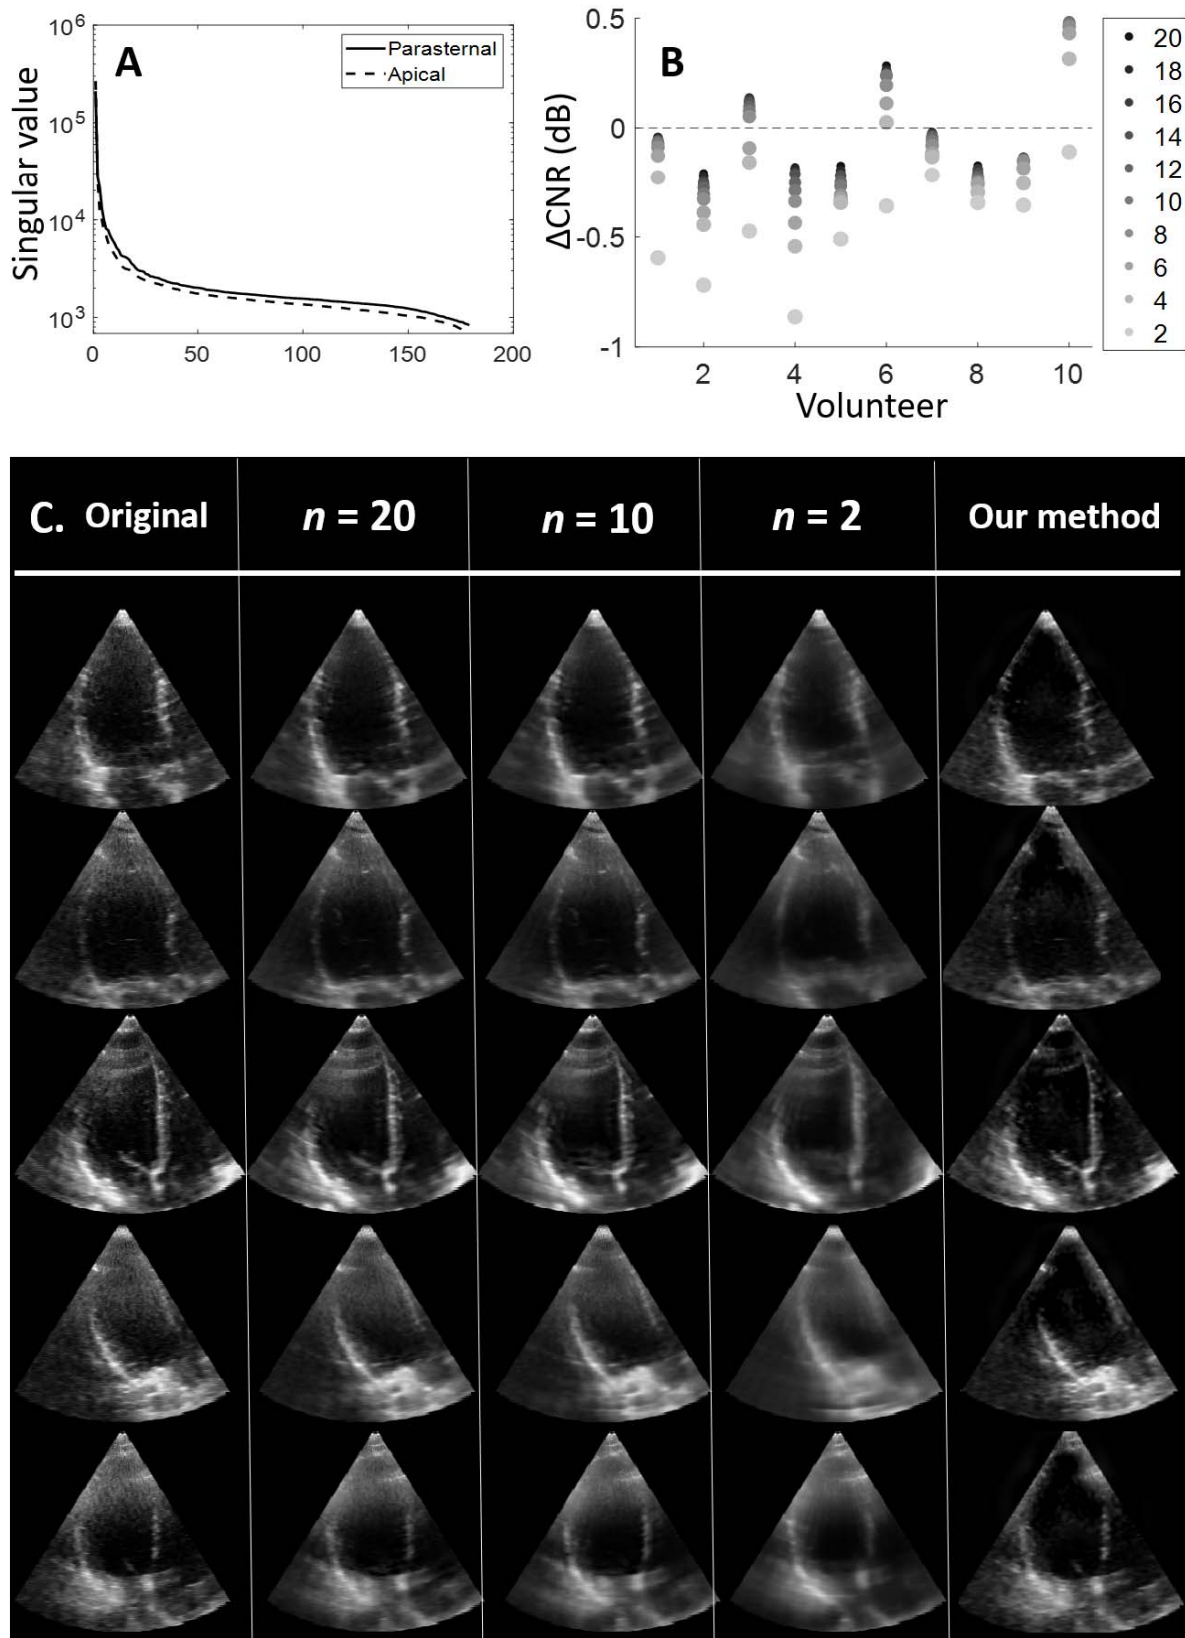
Comparison to a state-of-the-art spatio-temporal SVD filter. (a) Average singular values of the matrix S ordered from biggest to smallest for the apical and parasternal data sets. (b) Changes in CNR values after application of the SVD filter. For each volunteer, the average ΔCNR is computed for different values of the singular value threshold n . The ΔCNR becomes smaller with a reduction in n , thus with discarding less information. (c) Examples of the effect of the SVD filter on the 3-D echocardiography images. With a decline in n , an increase in elimination of small structures (e.g., NF clutter particles, US speckle) can be observed, resulting in the blurring of the images. In contrast to the proposed method, the white NF clutter haze still remains visible.
